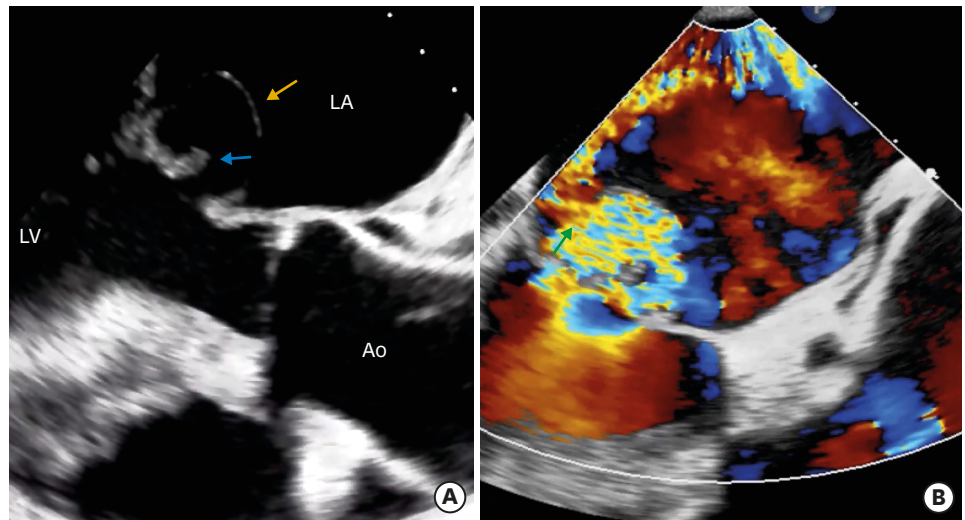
Transesophageal echocardiogram (3-chamber view). (A) Anterior mitral valve leaflet with large ruptured aneurysm (2.2 × 2.5 cm) (orange arrow) and a large moving mitral vegetation (blue arrow). (B) Transesophageal echocardiogram (2-chamber view). Color Doppler image showing severe mitral regurgitation through the ruptured aneurysm (green arrow). Ao: ascending aorta, LA: left atrium, LV: left ventricle.
